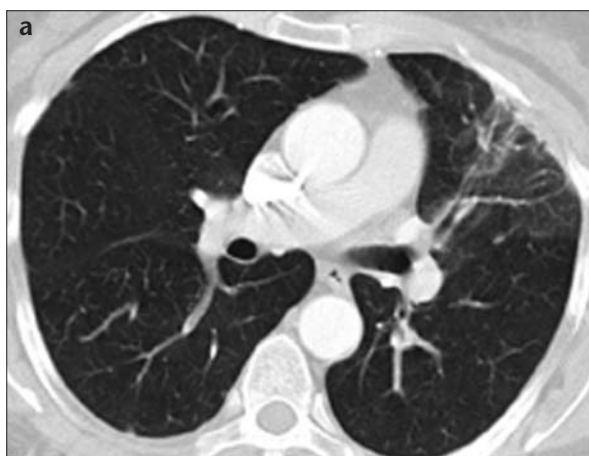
a, b. Disappearance of the lesion in the left lung is seen on follow-up CT 1 month after steroid treatment (a), but new peripherally-located ground glass densities are seen (b).
